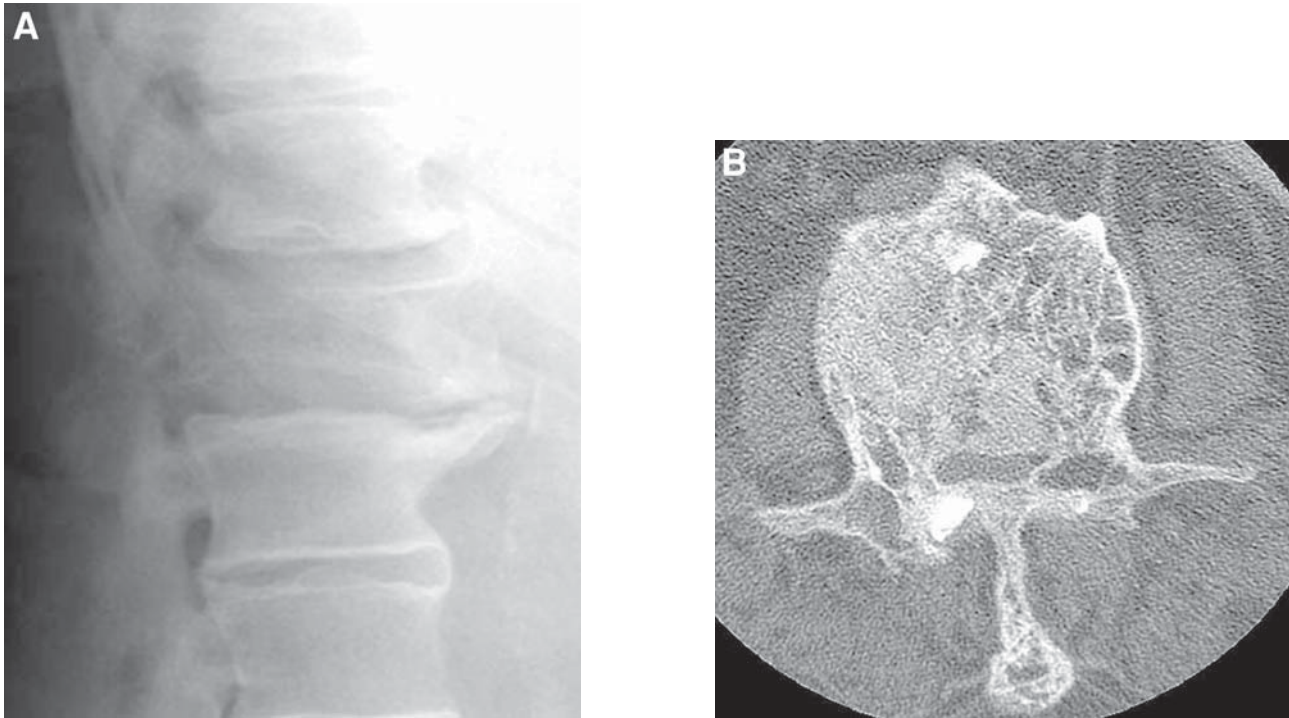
Lateral radiograph (A) displays a relatively lucent appearance of the L2 vertebral body with loss of height and some widening in the anteroposterior dimension. Axial CT (B) shows the characteristic features of Paget's disease with a coarse trabecular pattern and osseous expansion, which results in severe spinal canal stenosis.
